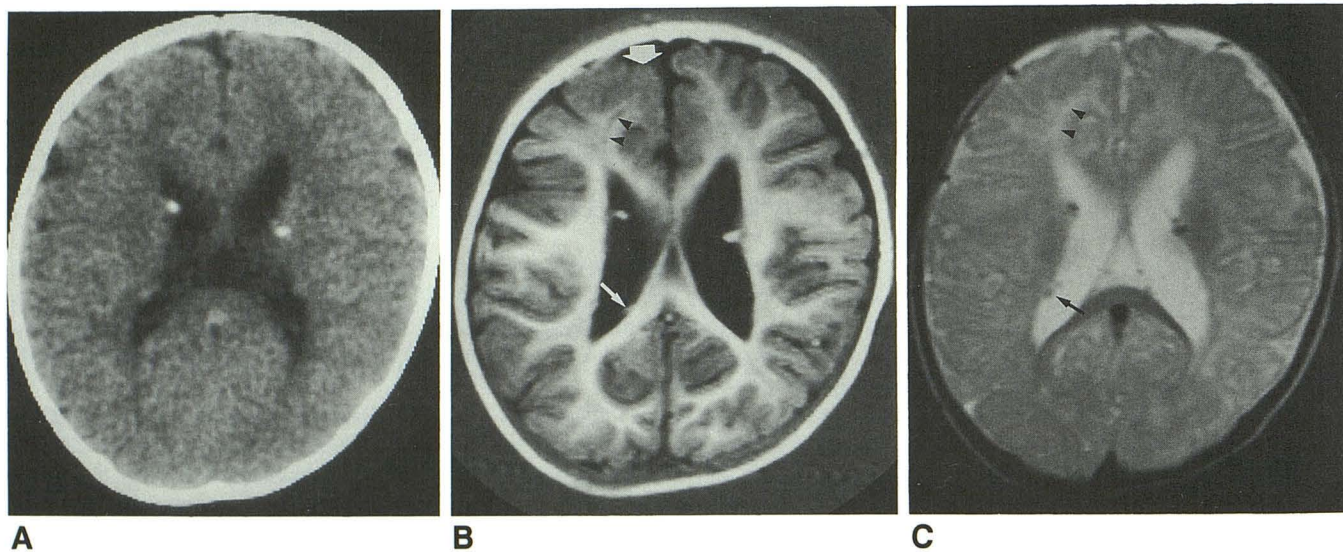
Case 1: 8-month-old-girl. Plain CT (A); T1-weighted MR image, IR 2500/30/600 (B); and T2-weighted MR image, SE 2000/100 with MAST (C). The calcified subependymal nodules demonstrated on CT (A) are seen with same signal intensity as white matter on T1-weighted MR image (B). These are seen as signal voids on T2-weighted MR image (C). Furthermore, a nodule (*thin arrow* in B) is visible medial to atrium of right lateral ventricle, and nodules of same signal intensity as gray matter (*arrow* in C) are visible at posterolateral aspect of right lateral ventricle. Branching of right superior frontal gyrus is reduced, suggesting formation of a cortical tuber (*wide arrow* in B). In the subcortical lesion corresponding to the area of suspected cortical tuber, a line is seen as a hypointense area on the T1-weighted image (B) and as an area of somewhat higher intensity than surrounding white matter on T2-weighted image (C). It reaches the ventricular wall (*arrowheads* in B and C), but a subependymal nodule is not detectable at the ventricular site.
